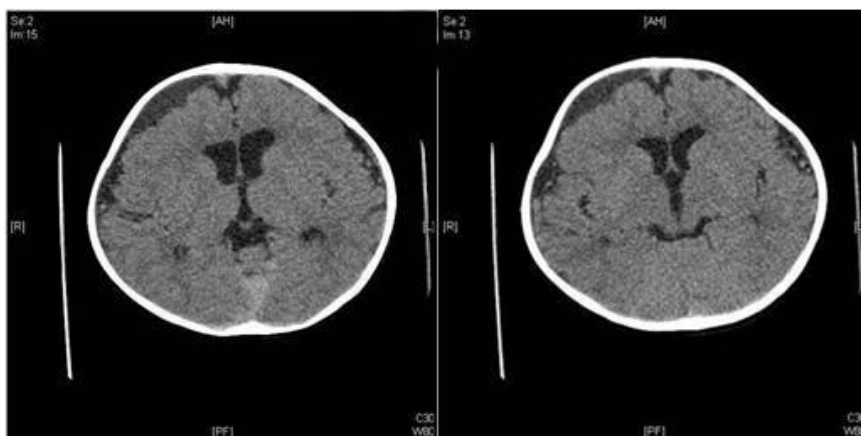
CT of the head after 5 months followup
